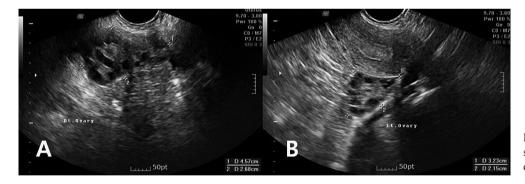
Transrectal sonographic finding (A: right ovary; B: left ovary).
